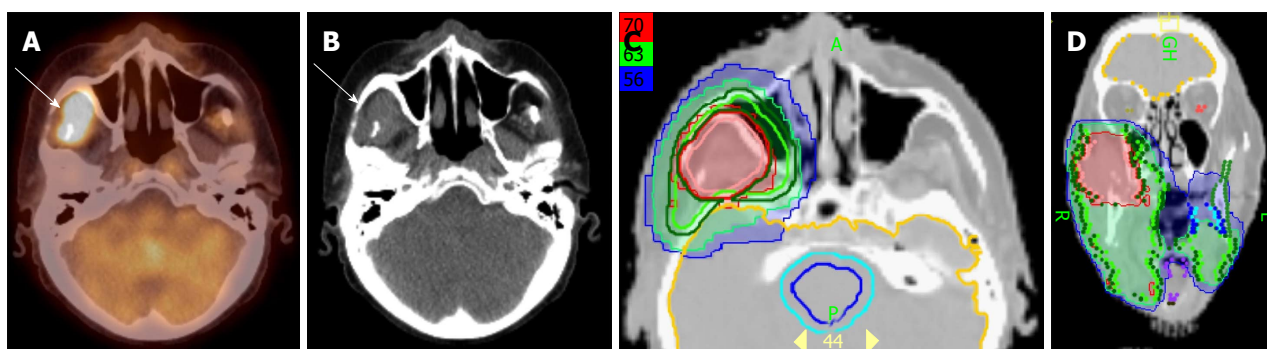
Positron emission tomography/computed tomography demonstrates tumor recurrence in a patient with a resected T4aN2b right buccal mucosa cancer prior to postoperative radiation. A-B: PET-CT obtained 50 d after surgery before postoperative radiation shows recurrent tumor (white arrow) in the infratemporal fossa; C-D: An IMRT treatment plan for this patient showing the recurrent tumor treated to a definitive radiation dose of 70 Gy rather than a typical postoperative radiation dose of 60 Gy. IMRT: Intensity modulated radiation therapy; PET/CT: Positron emission tomography/computed tomography.
